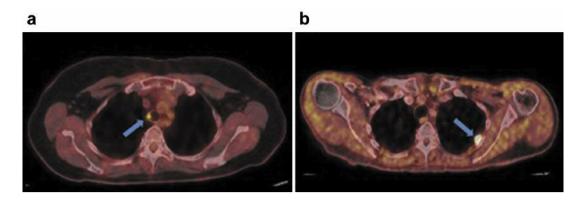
Cases of Asymptomatic HPV+ Recurrence Detection with PET-CT. Surveillance imaging such as PET-CT allows for detection of abnormalities that can be difficult to pick up symptomatically or on conventional physical exam. a) Distant asymptomatic trachea recurrence. b) Distant lung metastasis.
